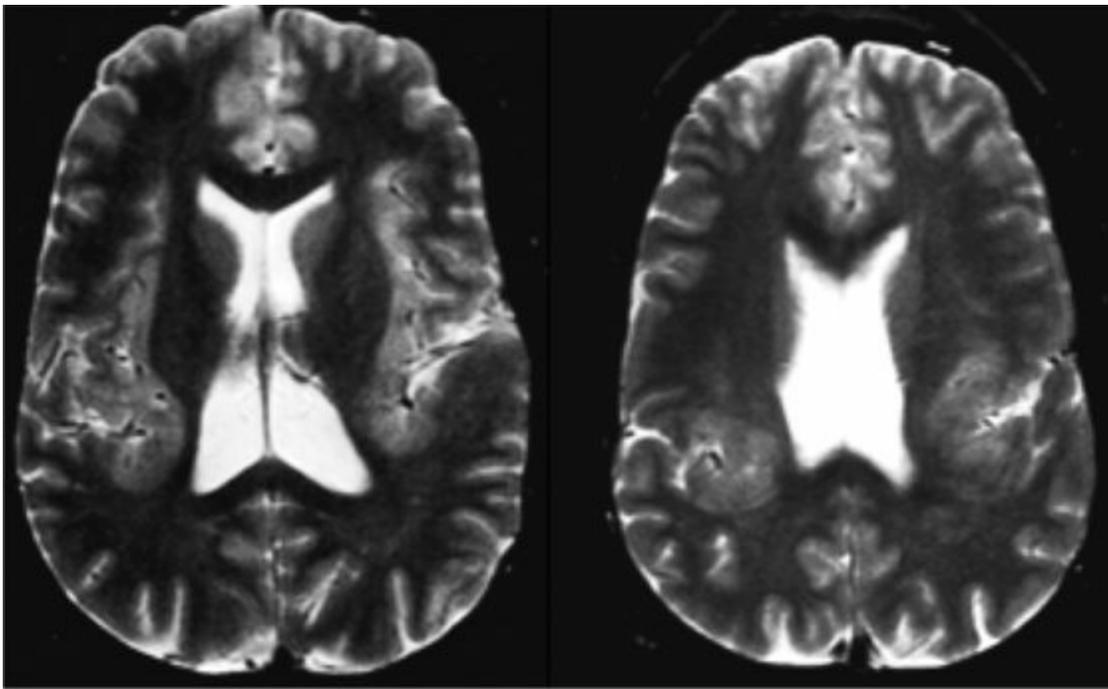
Congenital bilateral perisylvian syndrome (CBPS). The axial T2W MRI shows perisylvian PMG. The lesions are often asymmetric.
